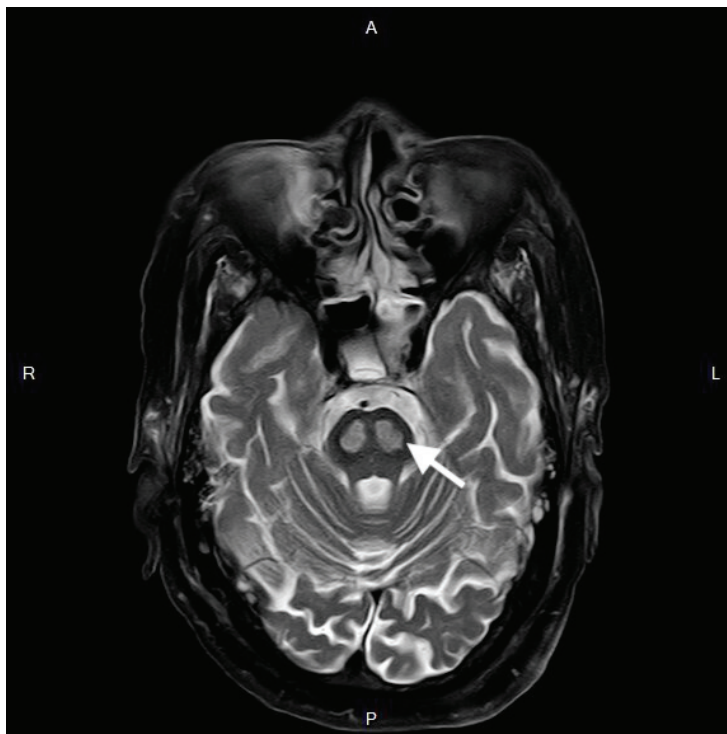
T2-weighted brain MRI revealed a typical "bat wing" or "butterfly" appearance on coronal view (white arrow).
